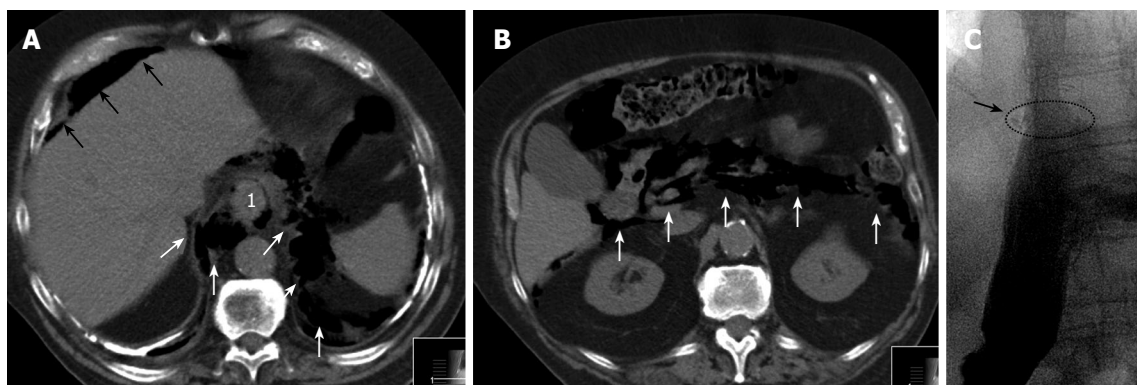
Pre- and postoperative radiographs. A and B: CT scan of the abdomen revealing free intra-abdominal air (A, black arrows) and massive mediastinal (A, white arrows) and retroperitoneal (B, white arrows) air. ¹Depicts the tumor localization at the GE junction; C: Water-soluble contrast medium swallowed after GE reconstruction (end-to-side esophago-gastrostomy) without evidence of anastomotic stenosis or leakage. The circle (arrow) points to the level of the anastomosis.
